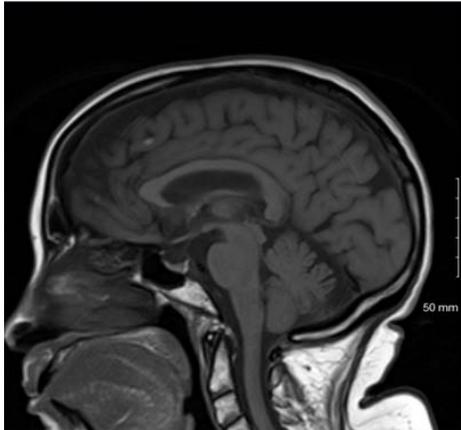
MRI head Sagittal T1 sequence showing no cerebellar atrophy.
